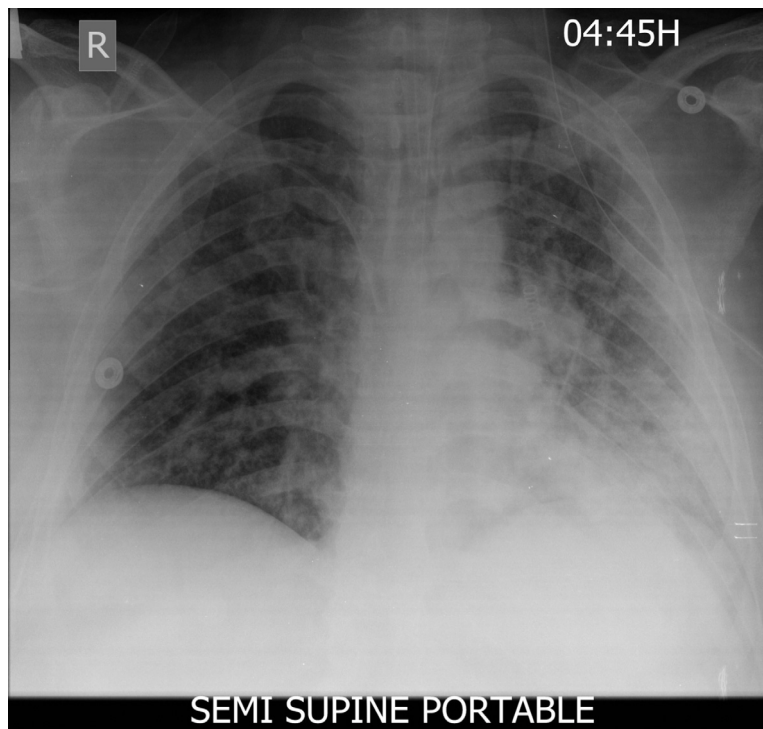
A case of MERS-CoV; Chest X-ray; frontal projection 18 days after admission showing partial regression of bilateral multifocal pulmonary opacities.
